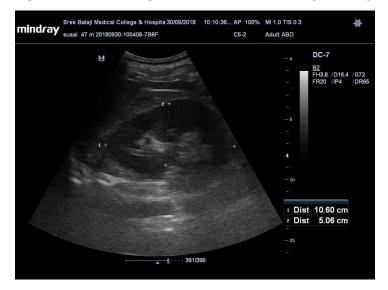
Ultrasound image of the measurement of left kidney
